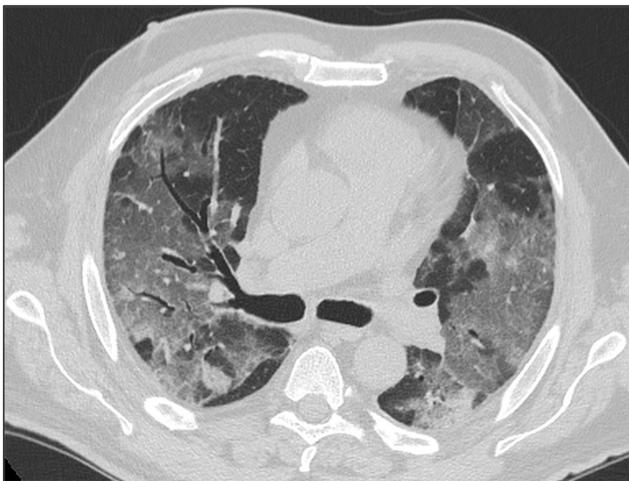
Axial chest computed tomography of a 67-year-old male affected by COVID-19, showing severe, diffuse, bilateral ground glass opacities and bronchiectasis which are typical features of viral infections.
